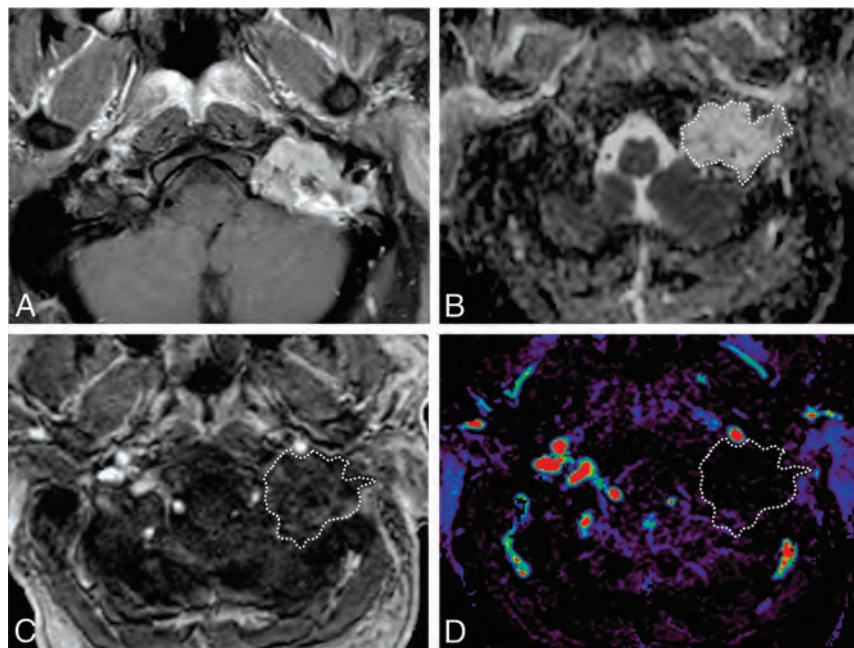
A 56-year-old man with a chondrosarcoma in the left petrous apex. A, Axial fat-saturated postcontrast T1-weighted image shows a heterogeneously enhancing mass in the left petrous apex. B, An ROI was placed on the ADC map, and the nADCmean was calculated. Mean ADC and ADC values in the medulla were 2.05, and $0.80 \times 10^{-3} \text{ mm}^2/\text{s}$, respectively. The nADCmean was 2.56. C, An ROI was placed on the permeability map, and V_p , K^{trans} , and V_e were calculated. D, V_p is 0.01.
